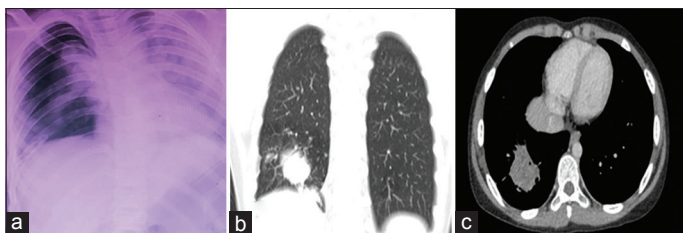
(a) X-ray and (b) high-resolution computed tomography chest suggestive of mass-like consolidation in the right lower lobe lung consolidation
